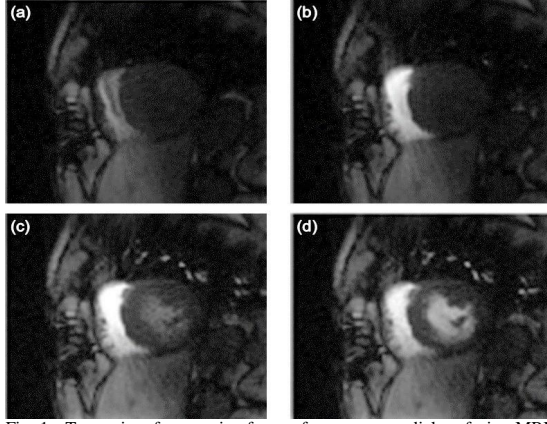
Two pairs of successive frames from a myocardial perfusion MRI image series. The first pair ((a) and (b)) are during the arrival of contrast agent in the right ventricle and the second pair ((c) and (d)) are during the arrival of contrast agent in the left ventricle. This serves to show that the contrast profile is not necessary similar between two successive frames.
